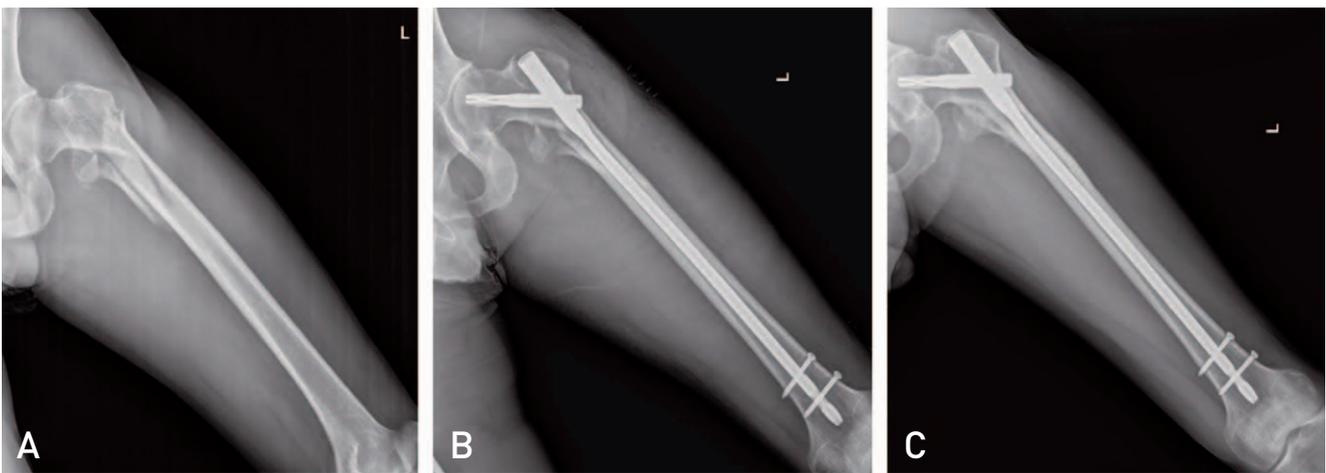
Plain radiographs of comminuted subtrochanteric fracture of a 53-year-old male patient. (A) Preoperative radiograph. (B) Immediate postoperative radiograph. (C) Post-operative 8 months follow-up radiograph.
